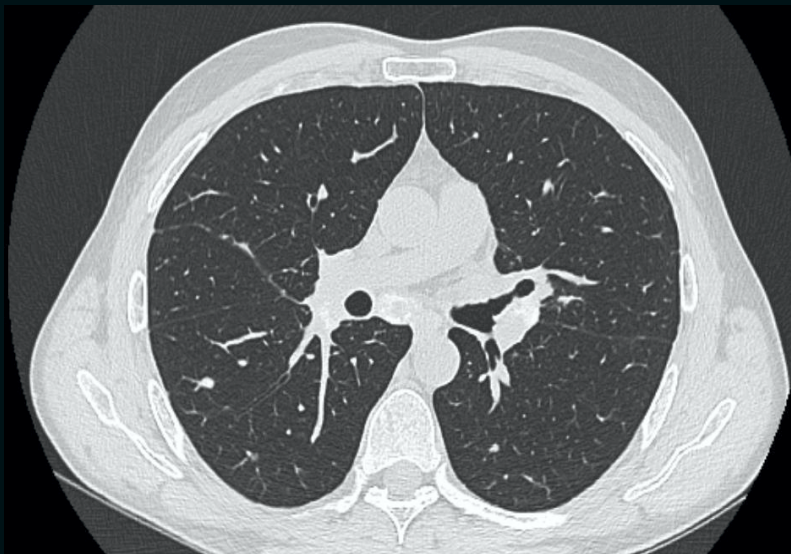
Chest CT re-examination after 6 months: Multiple bilateral pulmonary nodules, regressing in size compared to the previous examination
